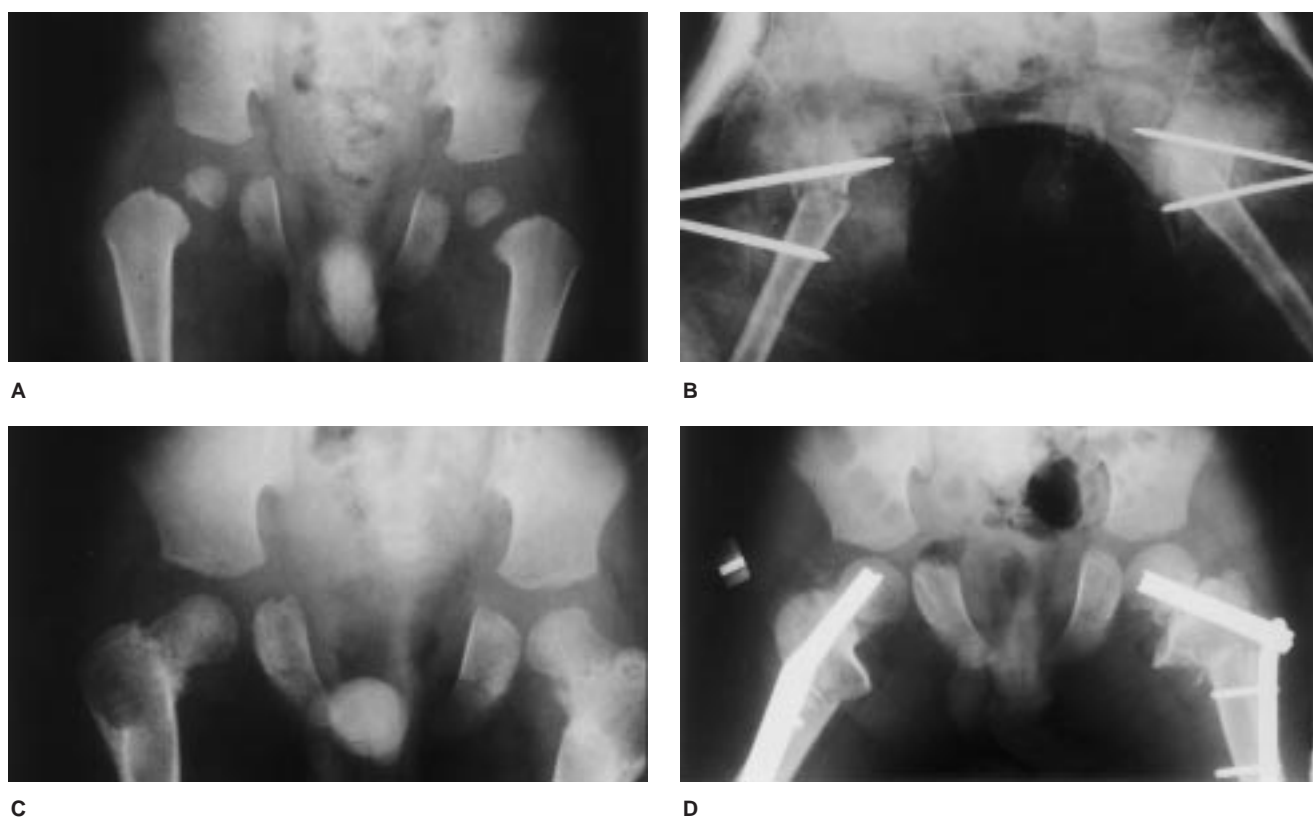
A, AP radiograph of the pelvis of a 3-year-old child with cleidocranial dysplasia shows delay in ossification of the pubis, widening of the triradiate cartilage and femoral physis, and early coxa vara. B, Progression of deformity was treated at age 4 by valgus-producing osteotomies. C, Radiograph at age 5 demonstrates healed subtrochanteric osteotomies with early redevelopment of coxa vara and narrow physes. D, Radiograph at age 8 depicts repeat valgus osteotomy. Transphyseal fixation was used because of recurrence of deformity.
